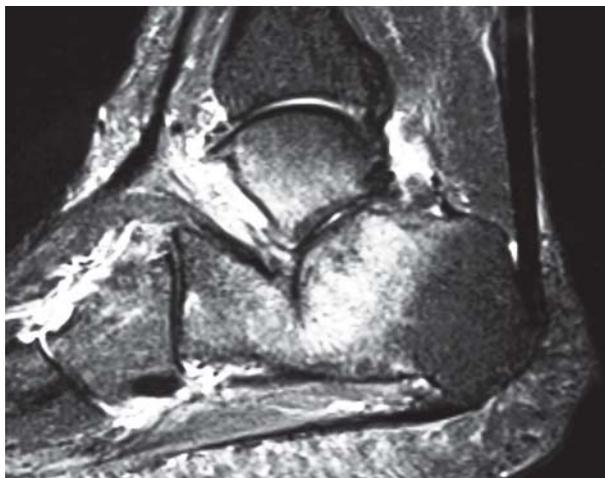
T2-weighted MRI showing high signal in the calcaneus
